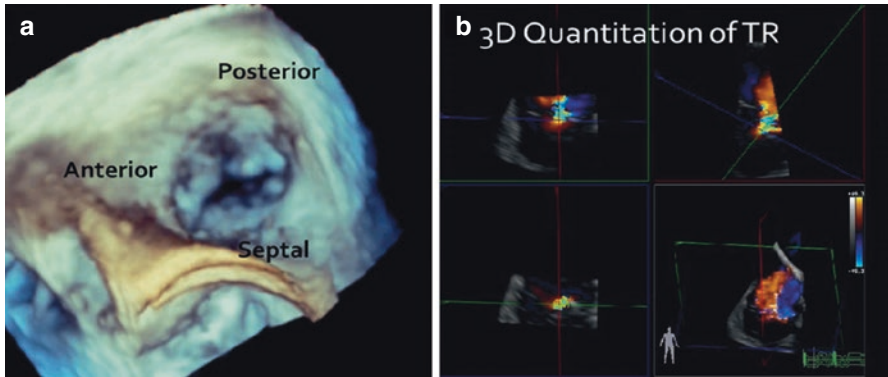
3D Imaging of the TV. The surgical view of the tricuspid valve (TV) (a) places the interatrial septum inferiorly (at the 6 o'clock position), regardless of the atrial or ventricular orientation. Using 3-dimensional (3D) color Doppler (b), the effective regurgitant orifice area can be used to quantify the severity of regurgitation. TR $\frac{1}{4}$ tricuspid regurgitation
